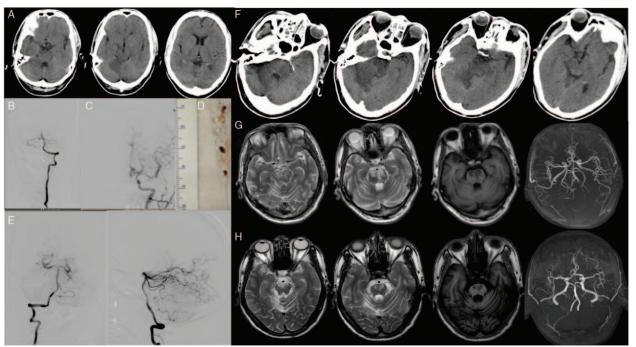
Cranial CT and DSA images of the patient. CT revealed hypointensity of the right cerebellum (A). Initial angiography via the left vertebral artery revealed upper and middle occlusions of the basilar artery (B). Angiography via the left internal carotid artery revealed that left posterior cerebral artery was visible via opening of the left posterior communication artery (C). (D) Thrombosis of 3 mm × 10 mm pulled by Solitaire-FR 6 mm × 30 mm stent. Successful recanalization was achieved after the procedure (E). On day 4 post-procedure, CT confirmed hypointensity of the pons and right cerebellum (F). Two weeks post-procedure, MRI revealed infarcts of the bilateral midbrain, pons, and right cerebellum. MRA confirmed the presence of basilar artery (G). At the 6-month follow up, MRI revealed old infarcts of the bilateral midbrain, pons and right cerebellum. MRA was normal (H). CT: Computed tomography; DSA: Digital subscription angiography, MRI: Magnetic resonance imaging; MRA: Magnetic resonance angiography.
